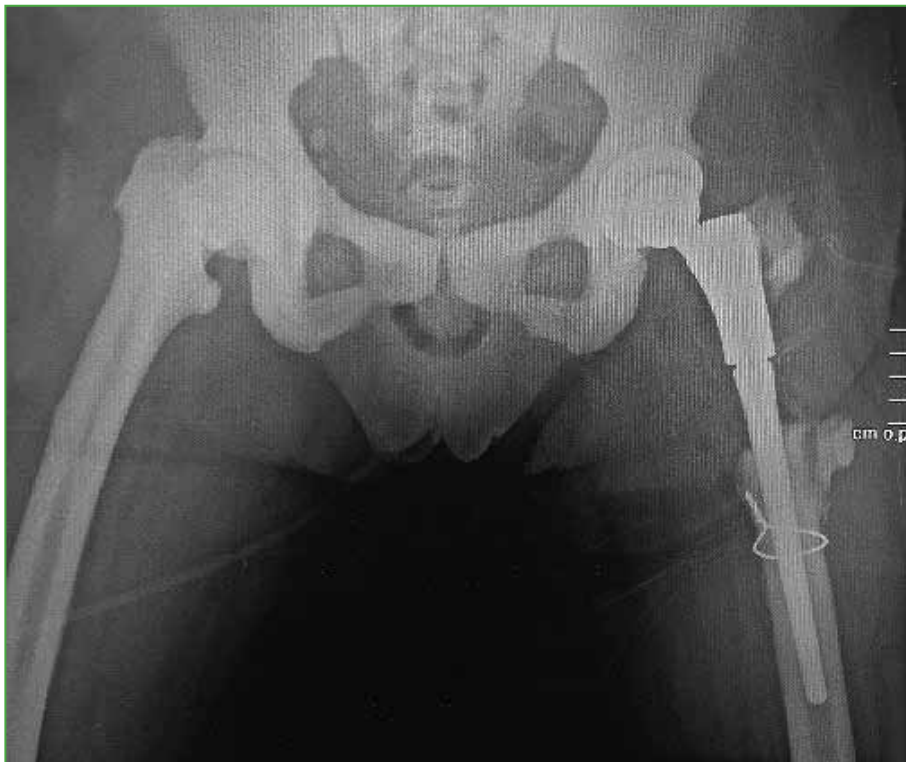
Postoperative control radiograph of open reduction of dislocation and reattachment of the hip abductor mechanism.
